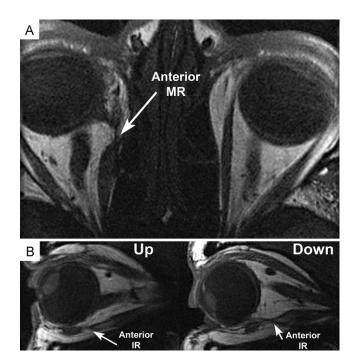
T1-weighted MRI scans of patients with muscle transections. A, Axial image of a patient with a medial rectus muscle (MR) transection deep in the orbit after endoscopic sinus surgery (arrow pointing to anterior portion of the transected muscle stump). B, Sagittal image of a patient with a traumatic inferior rectus (IR) muscle transection of the left eye (arrow pointing to anterior portion of the transected muscle stump). Residual contractility is revealed by contraction of the IR on downgaze (right panel) compared to relaxation on upgaze (left panel).
